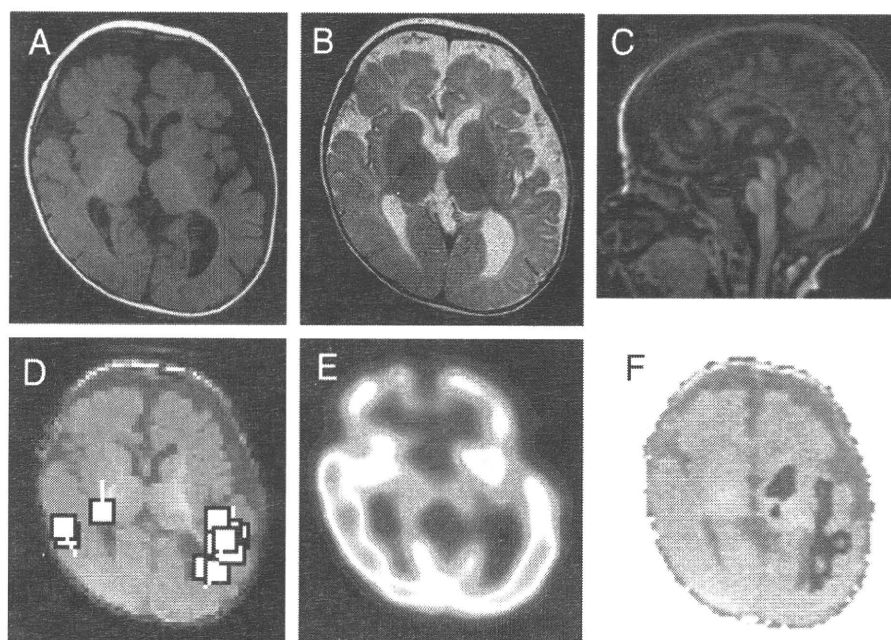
Neuroimaging of the patient. (A–C) Magnetic resonance images at the corrected age of 9 months. Myelination is visible in the posterior limb of the internal capsule, optic radiation, and deep white matter of the frontal lobe (A and C, T1-weighted images; B, T2-weighted image), which corresponds to the pattern of early infancy. (D–F: examined at the corrected age of 5 months) Magnetic electroencephalogram (D), interictal single-photon emission computed tomography (SPECT) (E), and subtraction of ictal SPECT coregistered to MRI (F) based on a brief tonic seizure.
